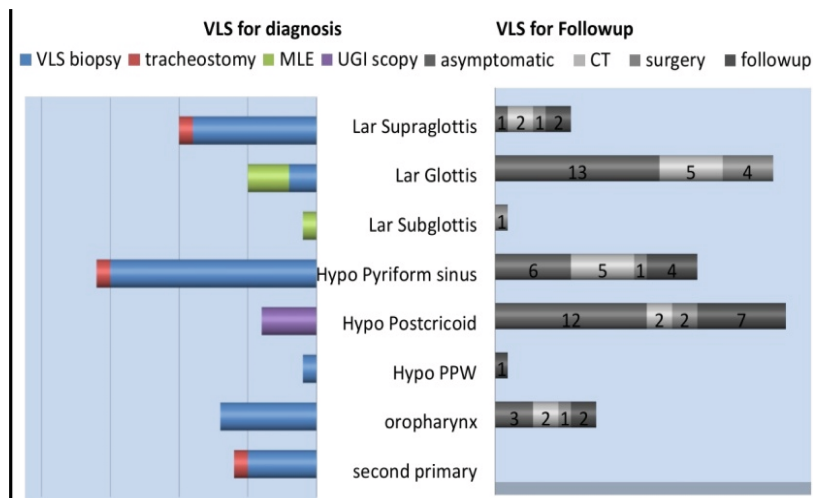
VLS outcome in carcinomas (VLS, videolaryngoscopy; MLE, microlaryngeal examination; UGI, upper gastrointestinal; CT, computed tomography; PPW, posterior pharyngeal wall).
